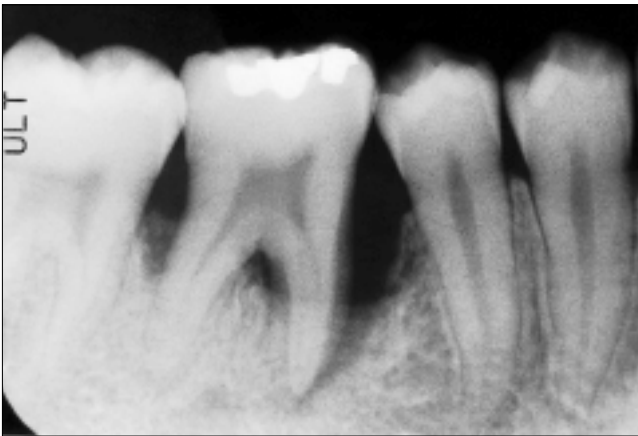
Periapical radiograph showing localized juvenile periodontitis associated with tooth 46.
